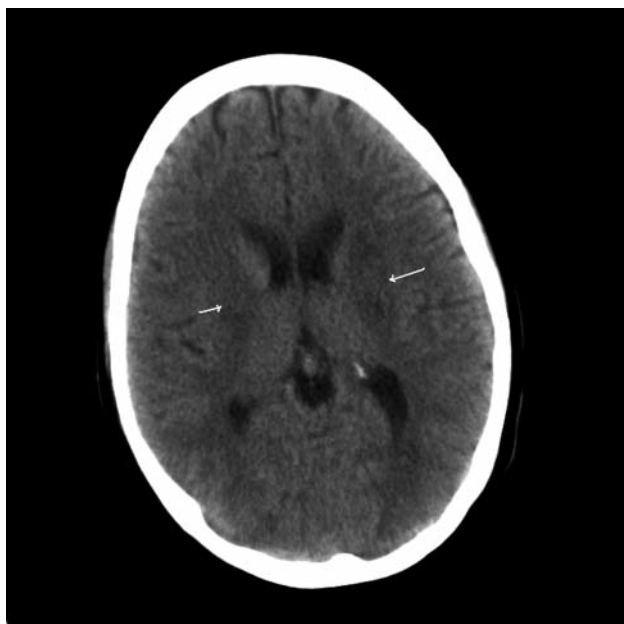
Transverse head CT scan obtained without intravenous contrast medium on day two postpartum. There are areas of low attenuation (hypodense) in the left ganglionic region and to a lesser extent to the right (white arrows). There is no intracranial hemorrhage. Differential diagnosis includes an embolic event and dural venous sinus thrombosis.
